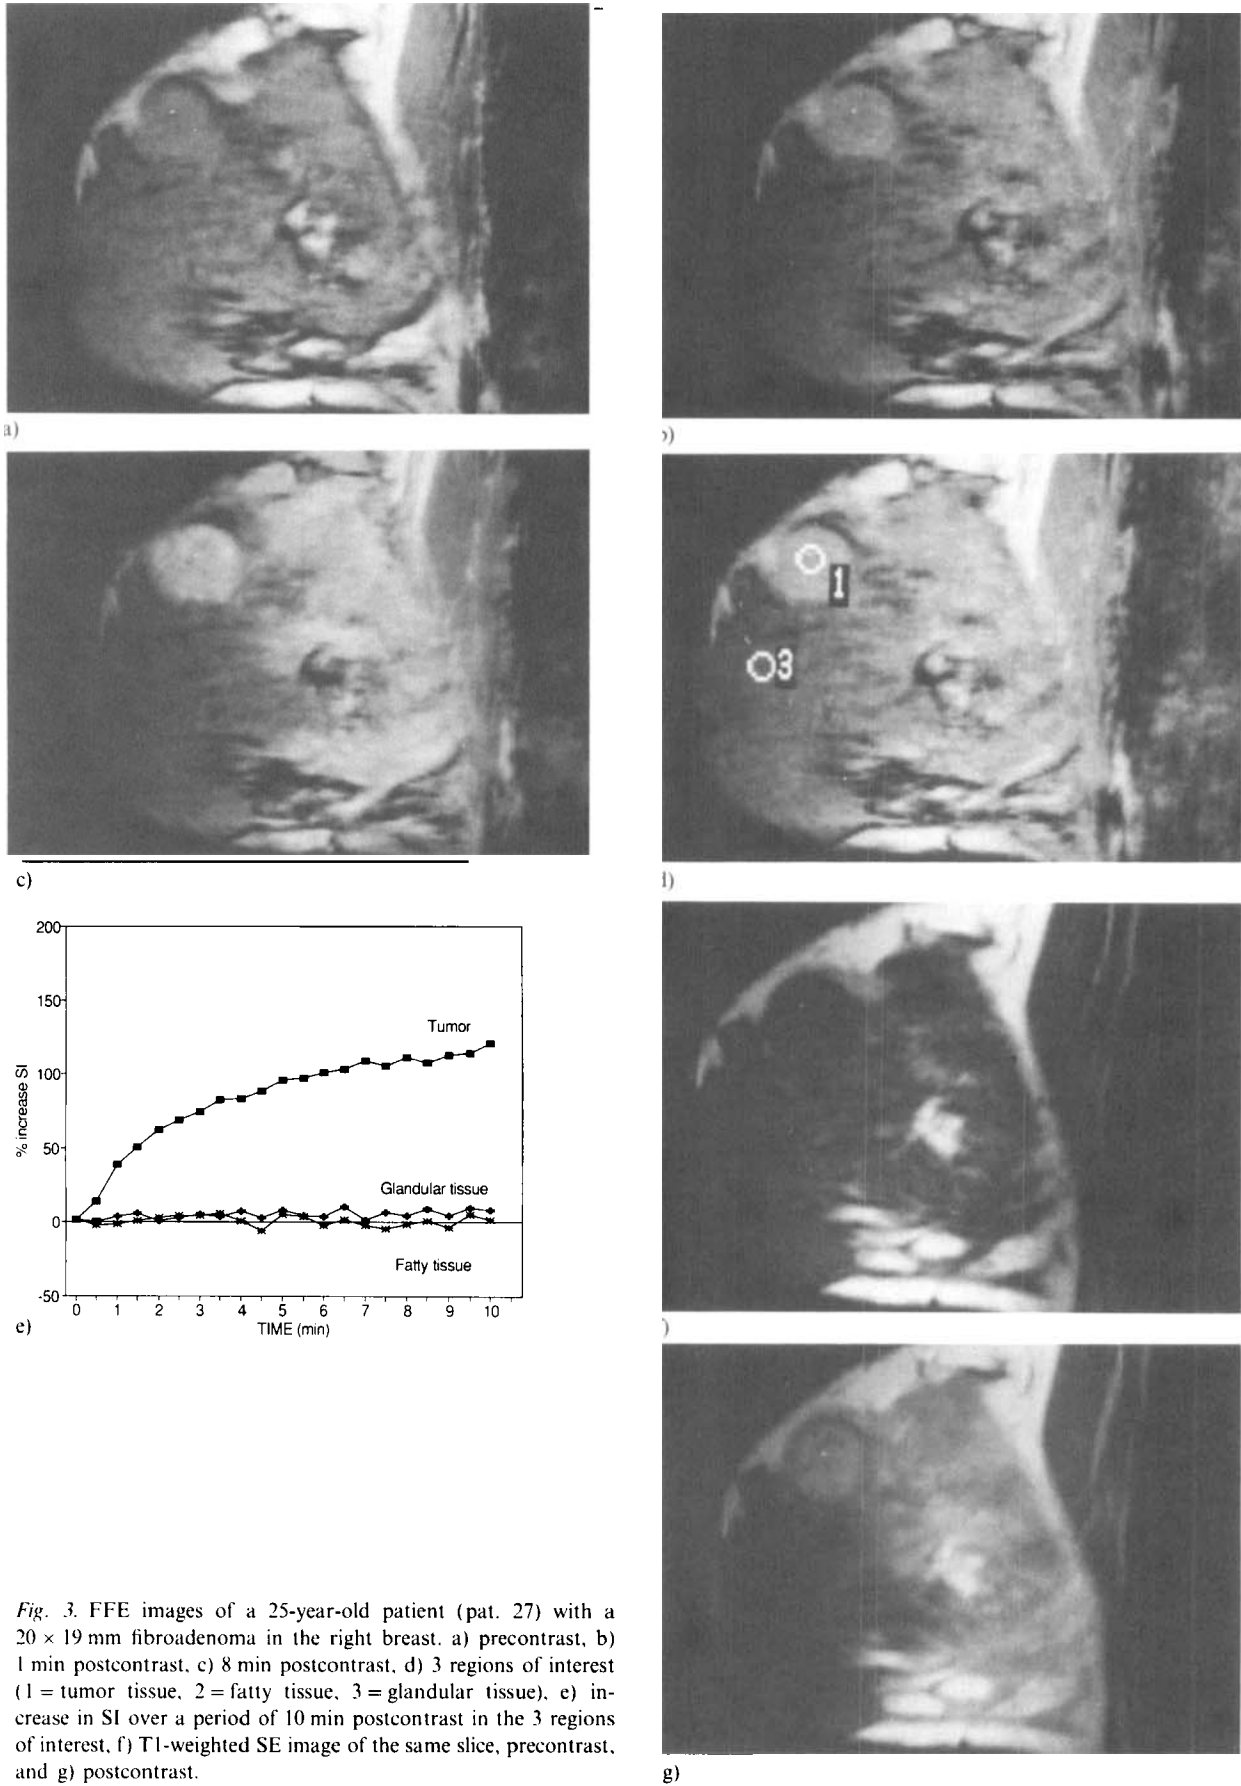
FFE images of a 25-year-old patient (pat. 27) with a 20 × 19 mm fibroadenoma in the right breast. a) precontrast, b) 1 min postcontrast, c) 8 min postcontrast, d) 3 regions of interest (1 = tumor tissue, 2 = fatty tissue, 3 = glandular tissue), e) increase in SI over a period of 10 min postcontrast in the 3 regions of interest, f) T1-weighted SE image of the same slice, precontrast, and g) postcontrast.
